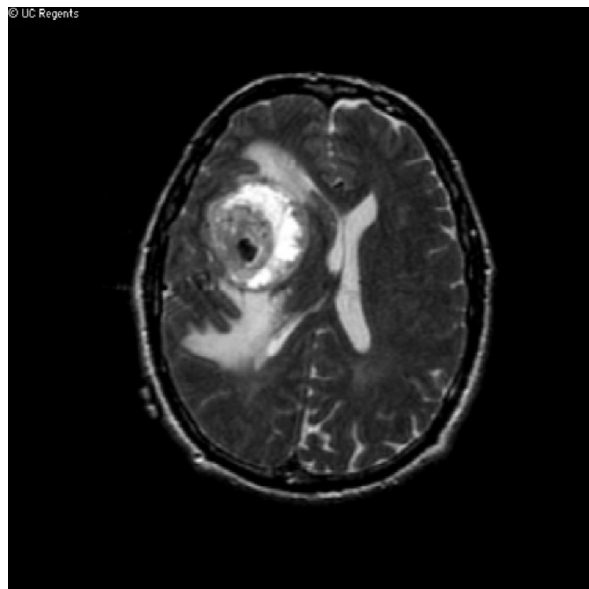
T2W FLAIR showing hyperintensity in the edema around the lesion
